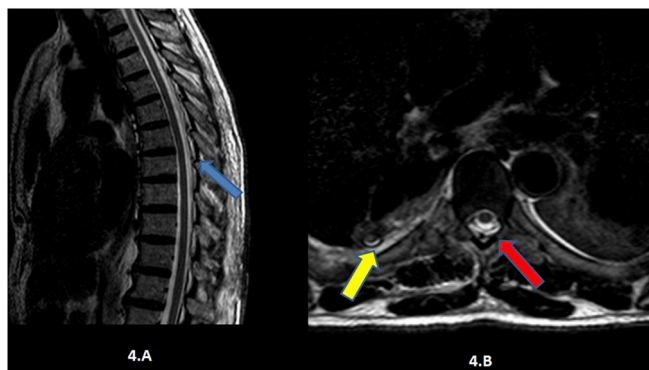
Thoracic MRI of the patient on admission. Sagittal (2.A) and axial (2.B) view. Presence of air in the spinal canal (blue arrow). Right costal fracture and hemothorax (yellow arrow) and intradural pneumorrhachis (red arrow).
